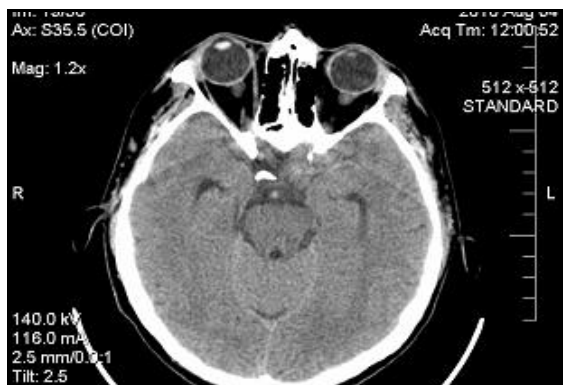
CT cerebral showing a SAH
